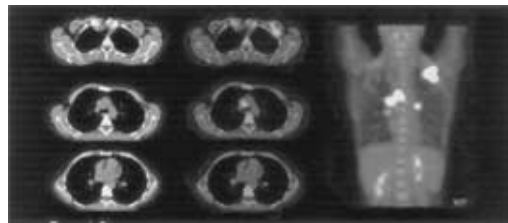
PET/CT images of a 37 year old female with metastatic breast carcinoma with increased uptake and activity following 400MBq FDG. Disease is demonstrated in the mediastinum, both hila and on the anterior left chest wall. Image courtesy of Siemens UK.
